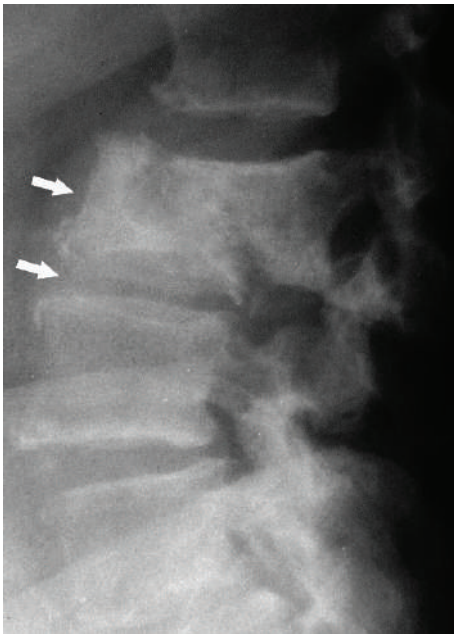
Lateral plain radiograph of the thoracic spine in a patient with thoracic Pott's disease shows destruction of the vertebral body and narrowing of the intervertebral disc space (*arrows*)
